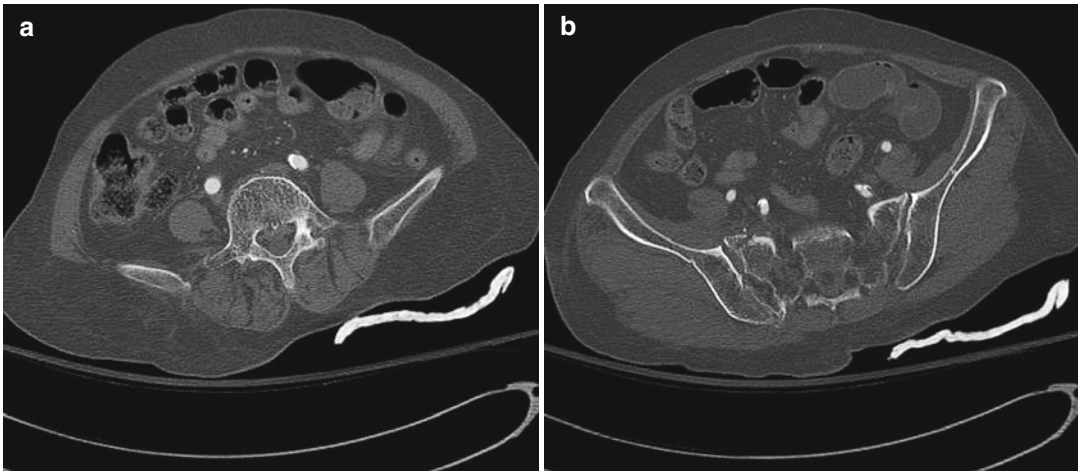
(a) and (b) Axial CT sequences transverse fracture at the tip showing right L5 transverse process fracture with associated right sacral ala fracture
